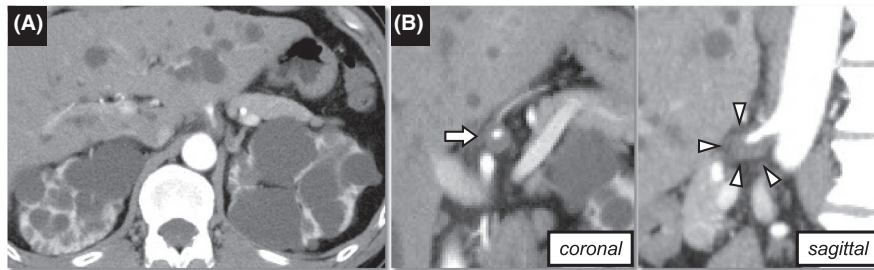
(A) Multiple renal and hepatic cysts were shown by contrast-enhanced computed tomography (CECT). (B) CECT showed celiac artery dissection with intramural hematoma only (left: arrow, coronal; right: arrowheads, sagittal)
